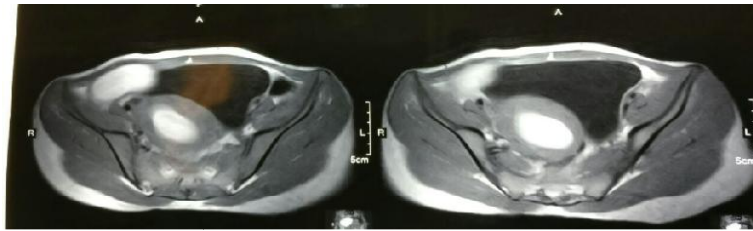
MRI showing hematosaphinx
